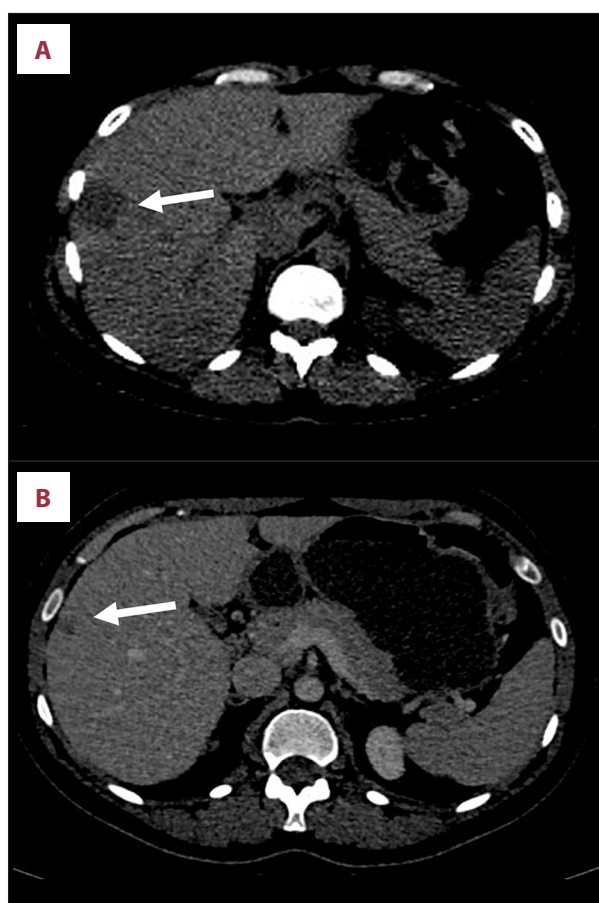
Abdominal CT images of liver metastasis without contrast enhancement. Axial view. (A) Hypodense structure in the fifth segment of the liver on positron emission tomography scan before the start of immunotherapy, (B) partial regression 3 months later, (C) complete regression 3 years after initiating immunotherapy. The white arrows indicate the location of the metastasis before and during therapy.
